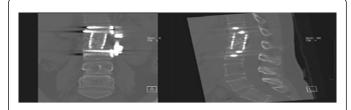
Stable bony unions were observed in the coronal A). and the sagittal B). images of the CT scan that was taken in 7 months after the operation.
